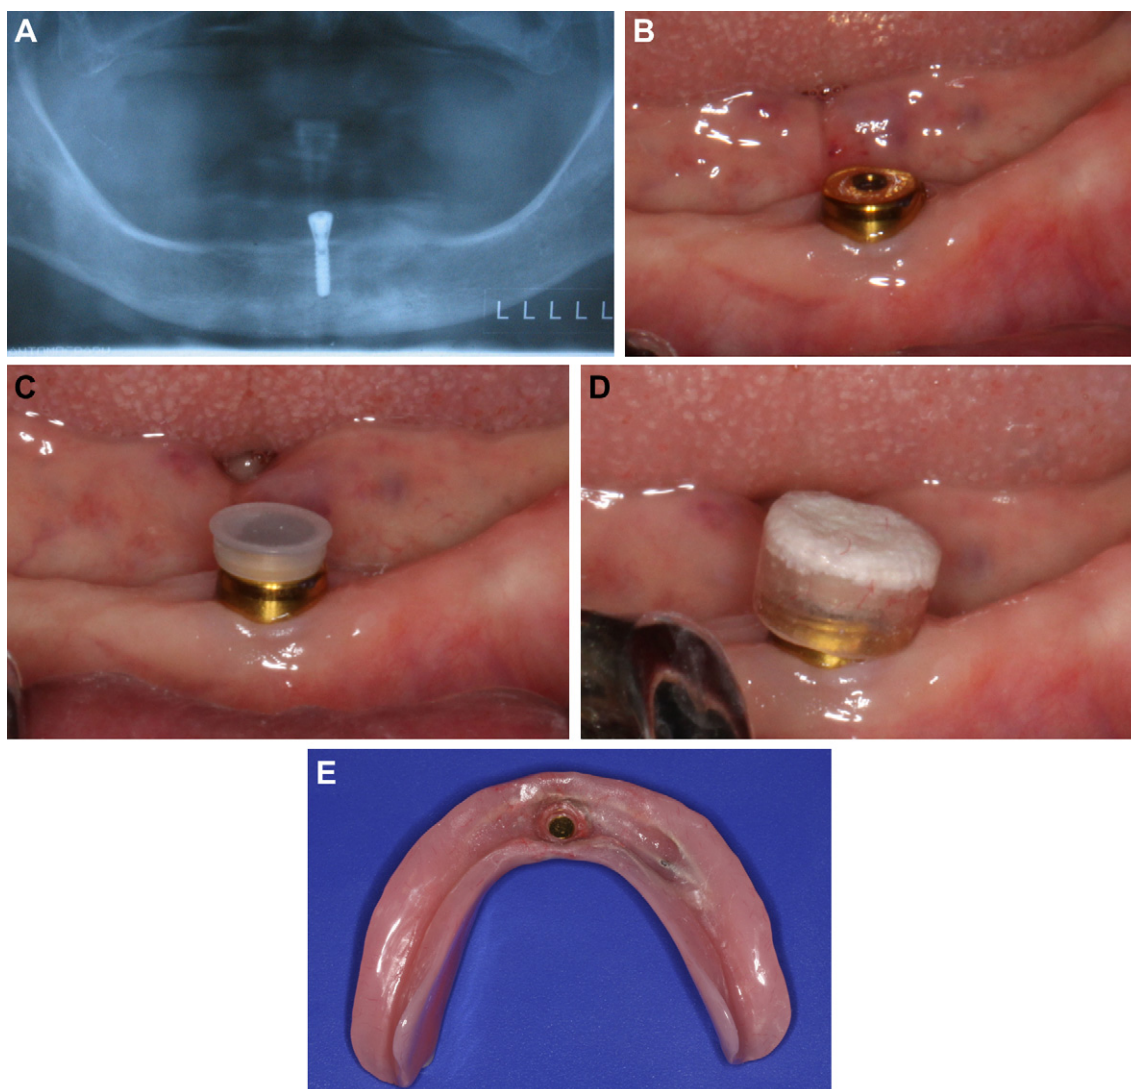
Placement of magnetic attachment after placing implant. (A) Frontal panoramic radiograph view of a symphyseal single implant; (B) occlusal view: fixing the keeper on the implant; (C) occlusal view: accurate match of the keeper and the magnet; (D) occlusal view: fixing the keeper and the magnet with self-curing acrylic resin; (E) basal view of overdenture with magnetic attachment.
